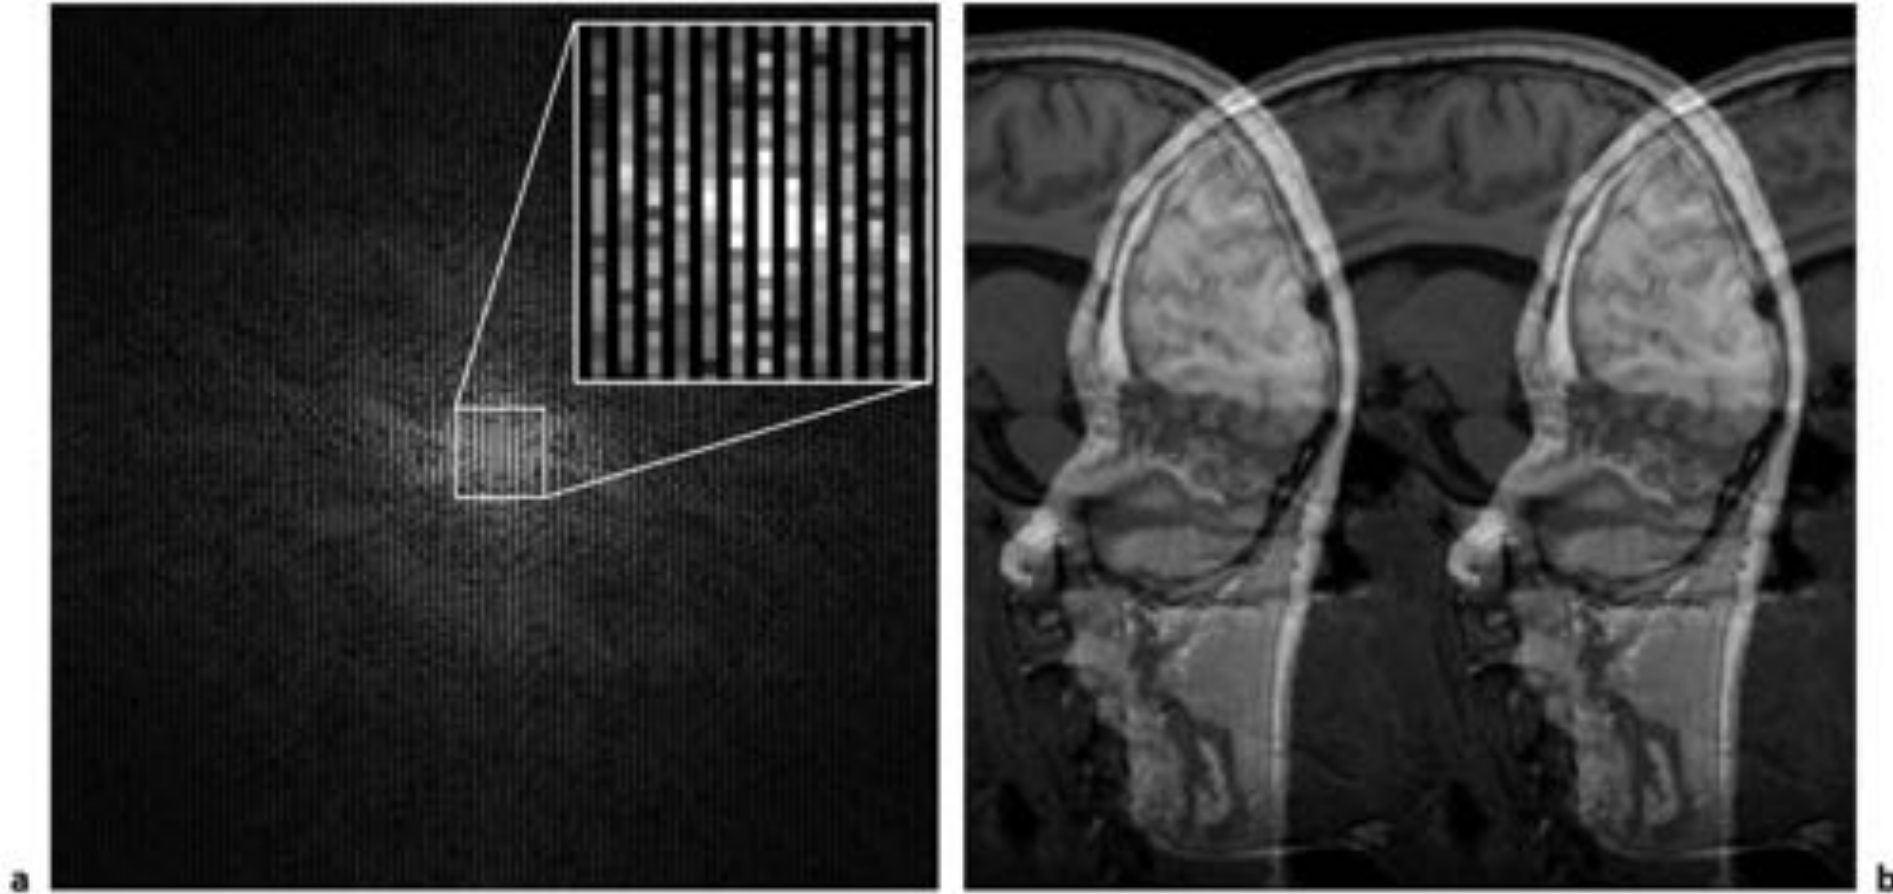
a Raw data after removing every other line in k-space and b corresponding reconstructed MR image. The effective field of view of the image is reduced to 50%, resulting in aliasing artefacts in anterior-posterior direction.
